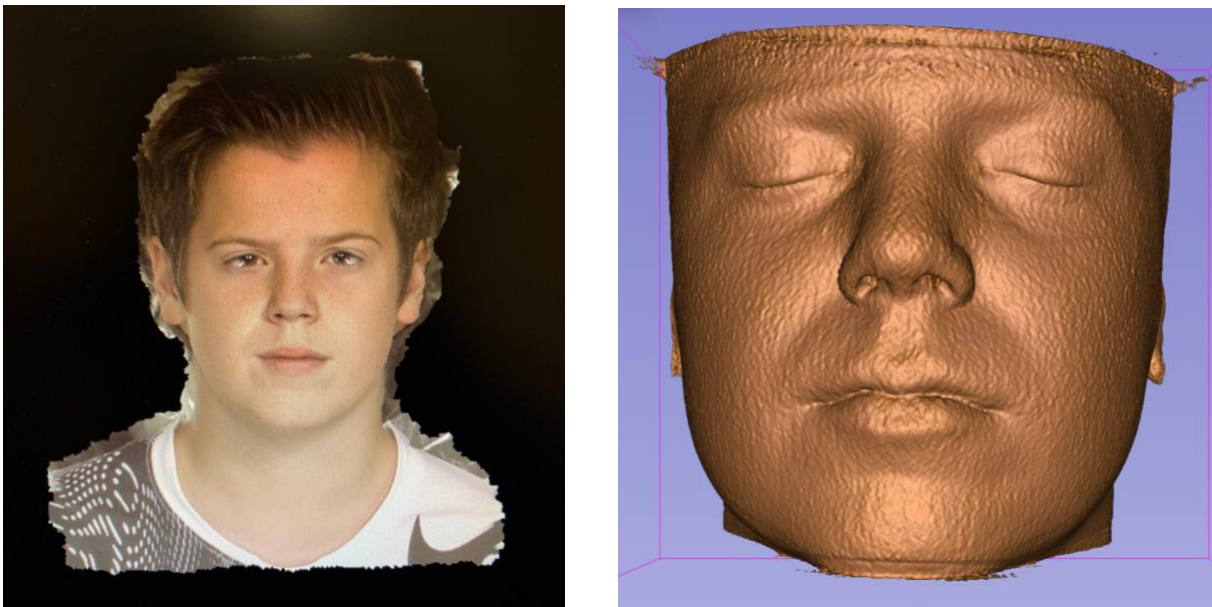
A: 3D facial scan (OrthoInsight 3D) and B: CBCT (3D slicer)
